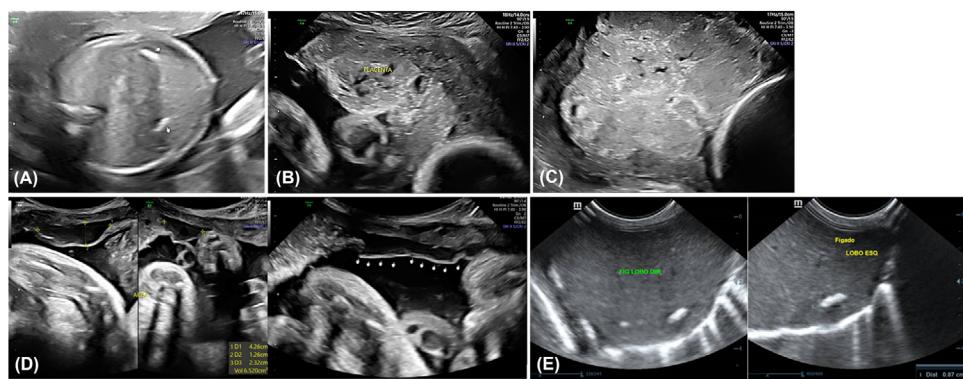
Ultrasound images at 25 weeks of gestation showing liver (A) and placental (B) calcifications. At 28 weeks of gestation, there was progression of calcifications and changes in placental shape (C). At 36 weeks of pregnancy, the patient presented amniochorial detachment (D). Two days after birth, the child had persistent calcifications in the right and left liver lobes (E).
